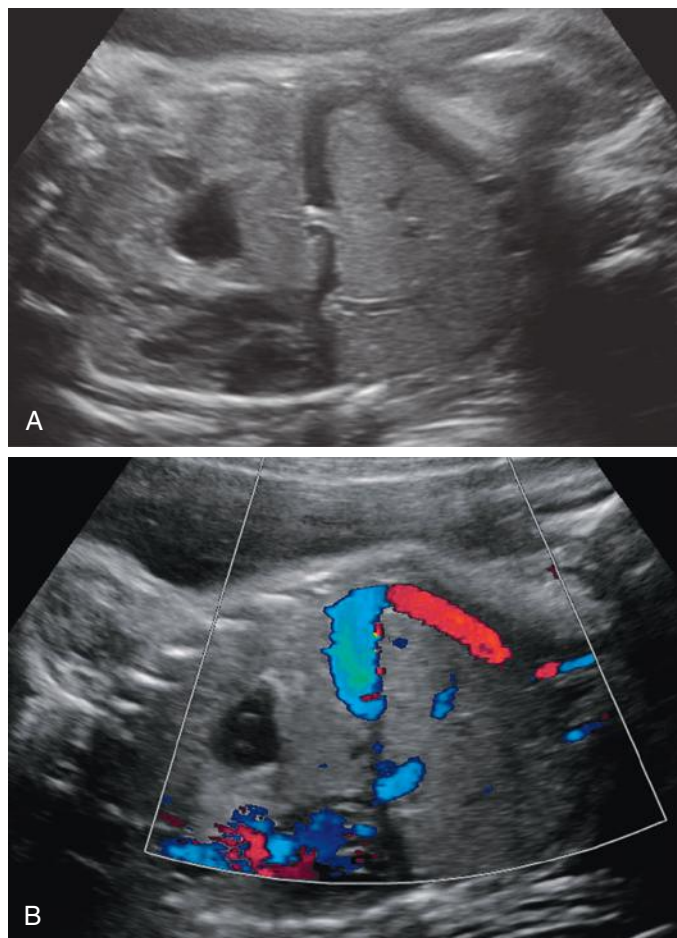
Left congenital diaphragmatic hernia (CDH). Coronal sonographic image (A) with liver herniation confirmed by color Doppler (B) showing flow in deviated umbilical/left portal vein.
